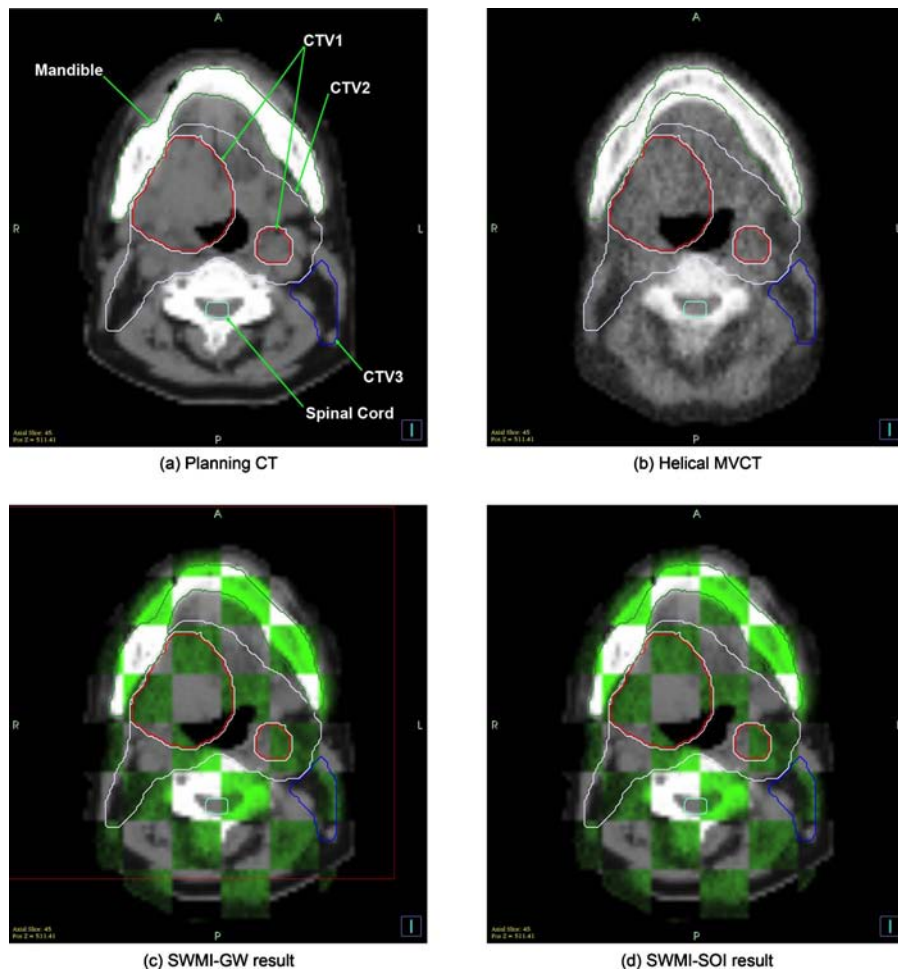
Image registration result for a head and neck image set with three CTVs. (a) Planning CT image with the contours of CTVs overlaid. (b) A helical MVCT of 31st day after the planning CT is taken. (c) The registration result of SWMI-GW. The rectangular box shows the $\pm 2\sigma$ boundary for SWMI-GW. (d) The registration result of SWMI-SOI.
